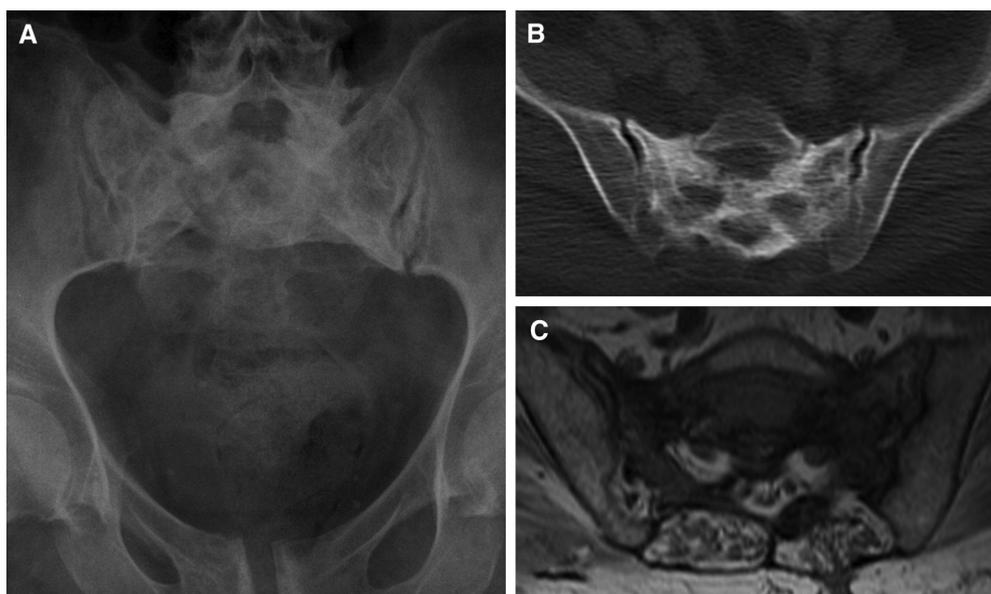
Sacral lymphoma. (A) Pelvic radiograph in a patient with lower back pain following a fall, showing diffuse sclerosis of the entire sacrum with trabecular coarsening, initially suspicious for Paget’s disease. (B) Axial computed tomography and (C) axial T1-weighted magnetic resonance imaging images confirm radiographic findings of diffuse sacral sclerosis and marrow replacement without evidence of sacroiliac joint involvement. Biopsy of this showed diffuse large B-cell lymphoma of bone.
